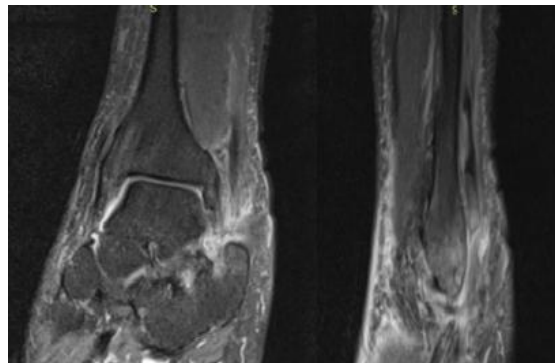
Ankle MRI showing a rupture of both peroneal tendons associated with tenosynovitis.
